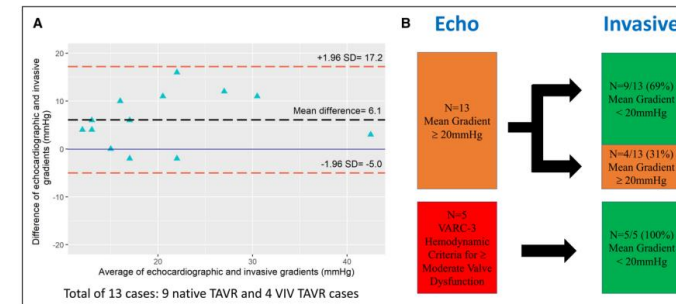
Discordance between echocardiography (echo) and standardized invasive hemodynamics (SIH).
